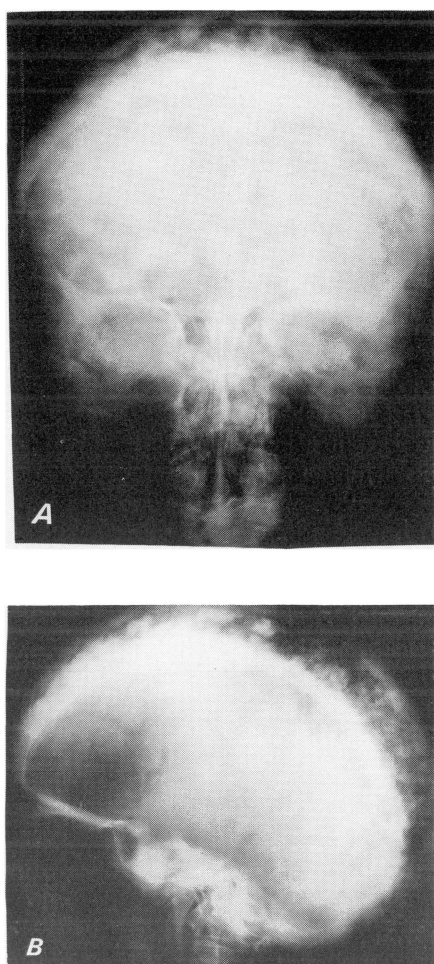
Roentgenogram of the skull. Both frontal (A) and lateral (B) views show severe Paget's disease with basilar invagination.
